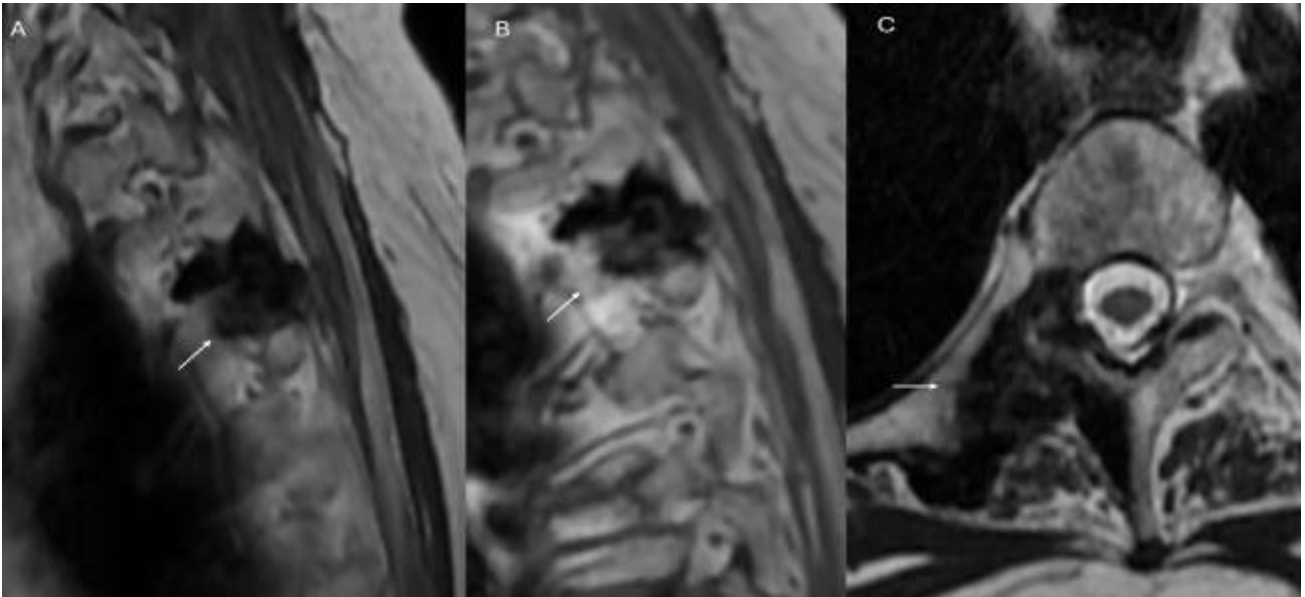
Magnetic resonance imaging of the thoracic spine demonstrating imaging features consistent with melorheostosis. (A) Sagittal T2-weighted image shows focal low signal intensity cortical thickening involving the posterolateral aspect of the D3 vertebral body (arrow). (B) Sagittal T1-weighted image demonstrates corresponding uniformly hypointense cortical hyperostosis without marrow replacement or expansion (arrow). (C) Axial T2-weighted image confirms eccentric cortical-based low signal thickening extending into the posterior elements and adjacent rib (arrow), with no surrounding marrow edema, epidural extension, or paraspinal soft tissue component.
